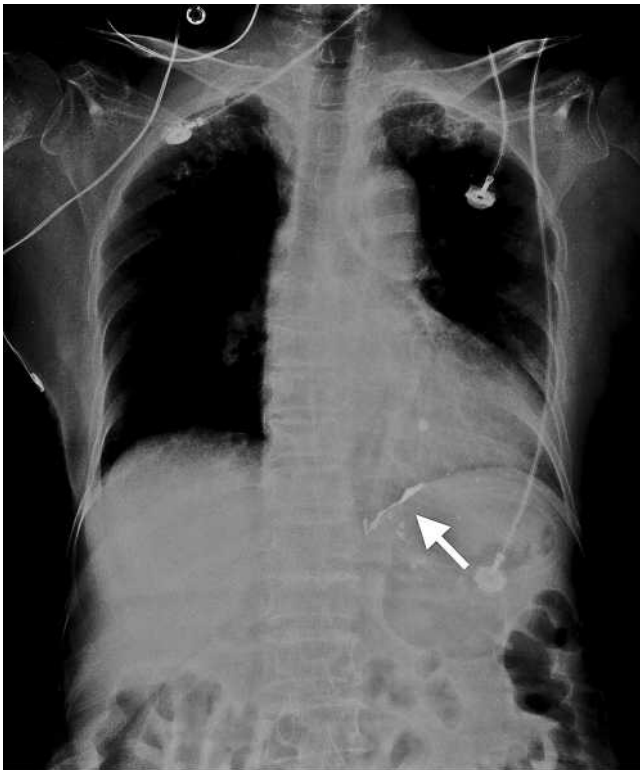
The chest radiograph showed radiopaque material along the left diaphragm (arrow).
